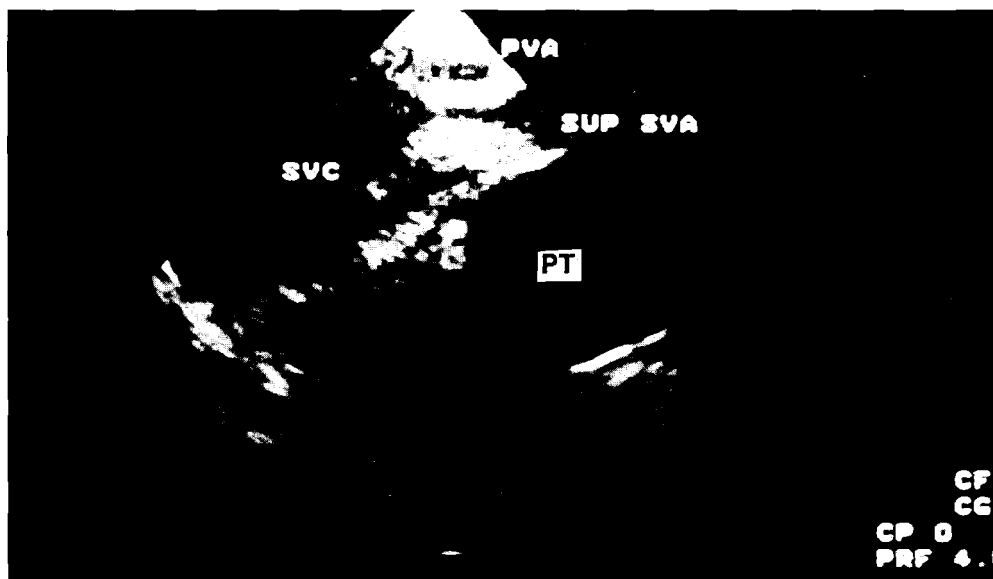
Transesophageal demonstration of an almost complete obstruction of the superior limb of the systemic venous atrium (SVA). The calcific stenosis and prosthetic baffle material reduces cross-sectional image quality.
